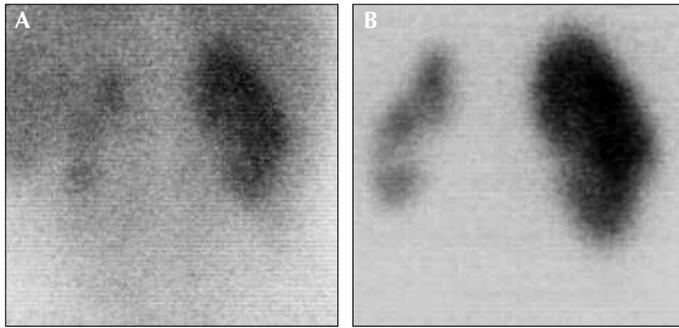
A six-year-old girl followed up with bilateral grade five VUR. ^{99m}Tc -MAG-3 (A) and ^{99m}Tc -DMSA (B) scintigraphies show the reduced sized of the left kidney in addition to multiple cortical scars and the normal size of the right kidney with cortical scarring in the middle region and lower pole. Structural damage to both kidneys was scored (score of 7 in the left kidney, score of 6 in the right kidney) and graded (grade III in both kidneys) by DMSA and MAG-3 scans
